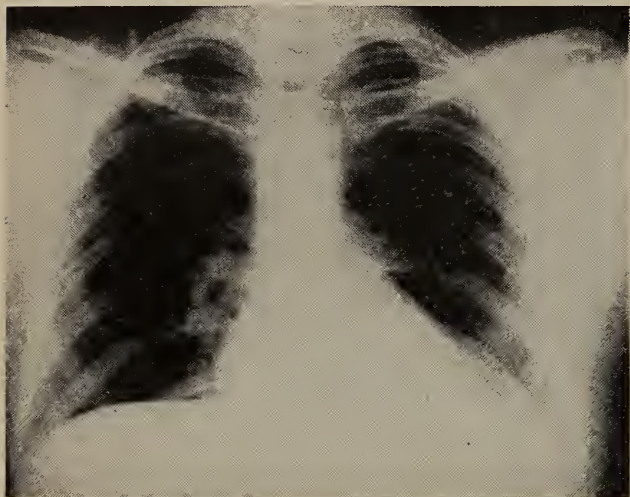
Chest x-ray, October, 1961, showing cardiac enlargement and left base subsegmental atelectasis and pleural reaction.
